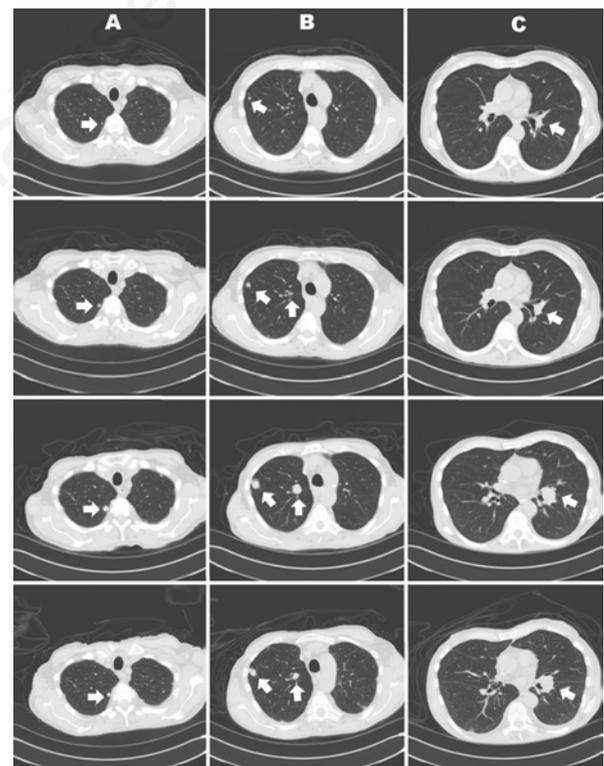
Computed tomography of the chest showing three separate lung nodules (Column A: nodule 1; Column B: nodule 2; Column C: nodule 3) at 15 weeks prior to starting pazopanib (first line), receiving temozolomide and CPT-11 (irinotecan) 7 weeks prior to starting pazopanib (second line), on no treatment; one day prior to starting pazopanib (third line); and 21 days after starting pazopanib (fourth line). Nodule 1: 7 weeks pre pazopanib, 5 mm; one day pre pazopanib, 11 mm; 21 days after starting pazopanib, 7.5 mm. Nodule 2: 7 weeks pre pazopanib, 9&6 mm; one day pre pazopanib, 20&19 mm; 21 days after starting pazopanib, 15&10 mm. Nodule 3: 7 weeks pre pazopanib, 14 mm; one day pre pazopanib, 27 mm; 21 days after starting pazopanib, 25 mm.
